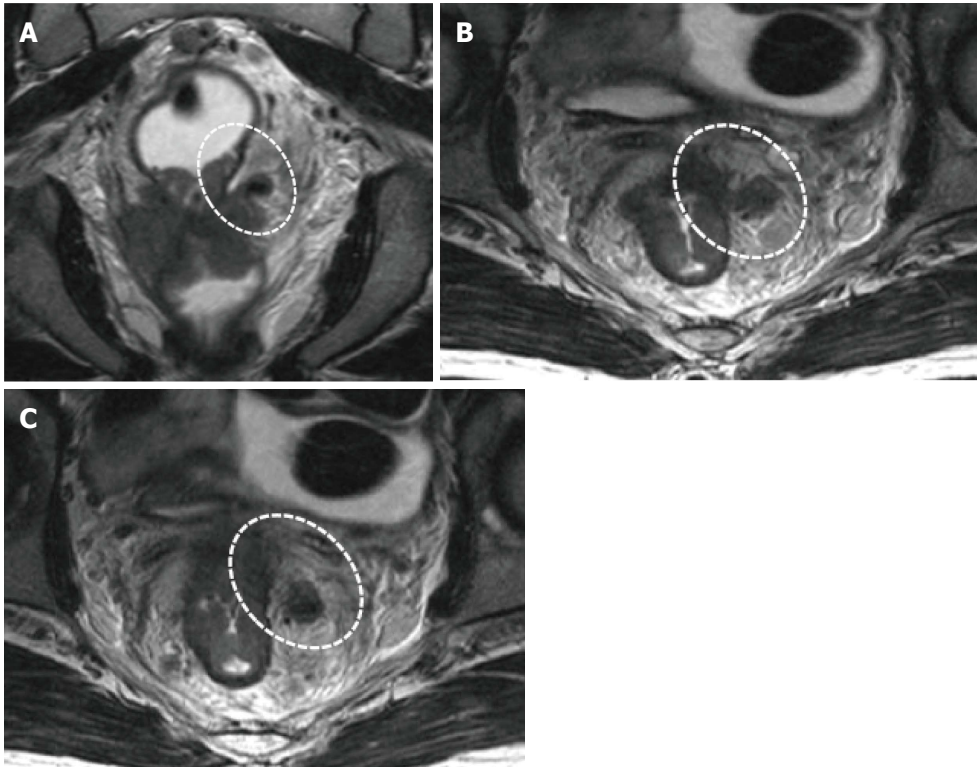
Extramural vascular invasion. T2-weighted (A) coronal and (B and C) serial axial magnetic resonance images in the same patient with T4a rectal cancer showing an irregular and expanded vessel insert to the tumor with tumoral signal intensity (circles).
